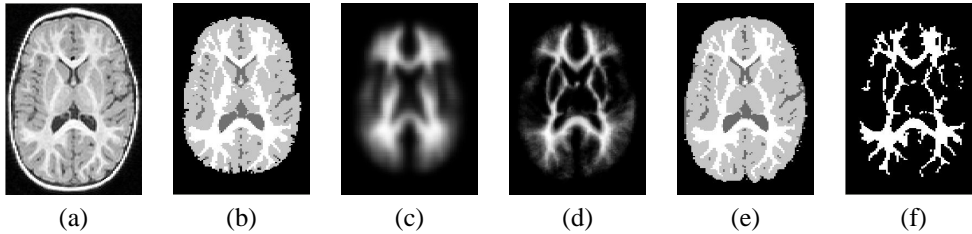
Improvement of segmentation using our new atlas: (a) MR image of a 2-year-old brain (b) segmentation using the 5 to 9-year-old CCHMC brain atlas (c) the 5 to 9-year-old CCHMC brain atlas (d) our 2-year-old brain atlas (e) segmentation using our 2-year-old brain atlas (f) manual segmentation
